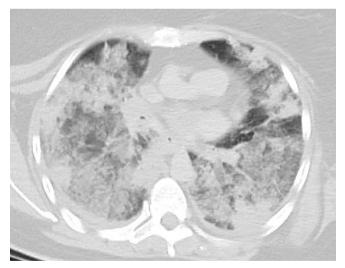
Case 1. Axial CT image of the chest (lung windows) showing bilateral, predominantly peripheral ground-glass opacities and consolidation. There are tiny, bilateral pleural effusions. Case history: A 70 year-old woman was found dead in her living room. She suffered from diabetes mellitus and ischaemic heart disease, and had a recent fever and cough. There were no notable findings on external examination. Additional PMCT findings were a small pericardial effusion and left ventricular hypertrophy. Coronary arteries showed minor calcification. There was no acute intracranial or intra-abdominal pathology and no fractures. Nose and throat swabs taken at the time of digital autopsy were positive for SARS-CoV-2 RNA. Cause of death: la COVID-19; II Diabetes mellitus.
